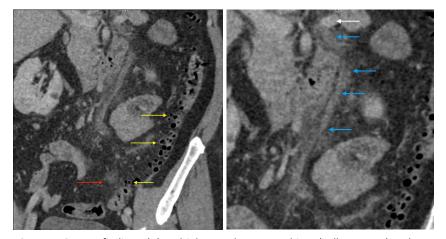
Contrast CT scan findings. (A) Multiple saccular outpouchings (yellow arrow) at the ascending, descending and sigmoid colon with fat stranding (red arrow) noted at the distal descending and proximal sigmoid colon. (B) Contrast study showing poor opacification of the inferior mesenteric vein (blue arrow) with surrounding fat stranding densities (white arrow) along the course of the IMV and its tributaries.
